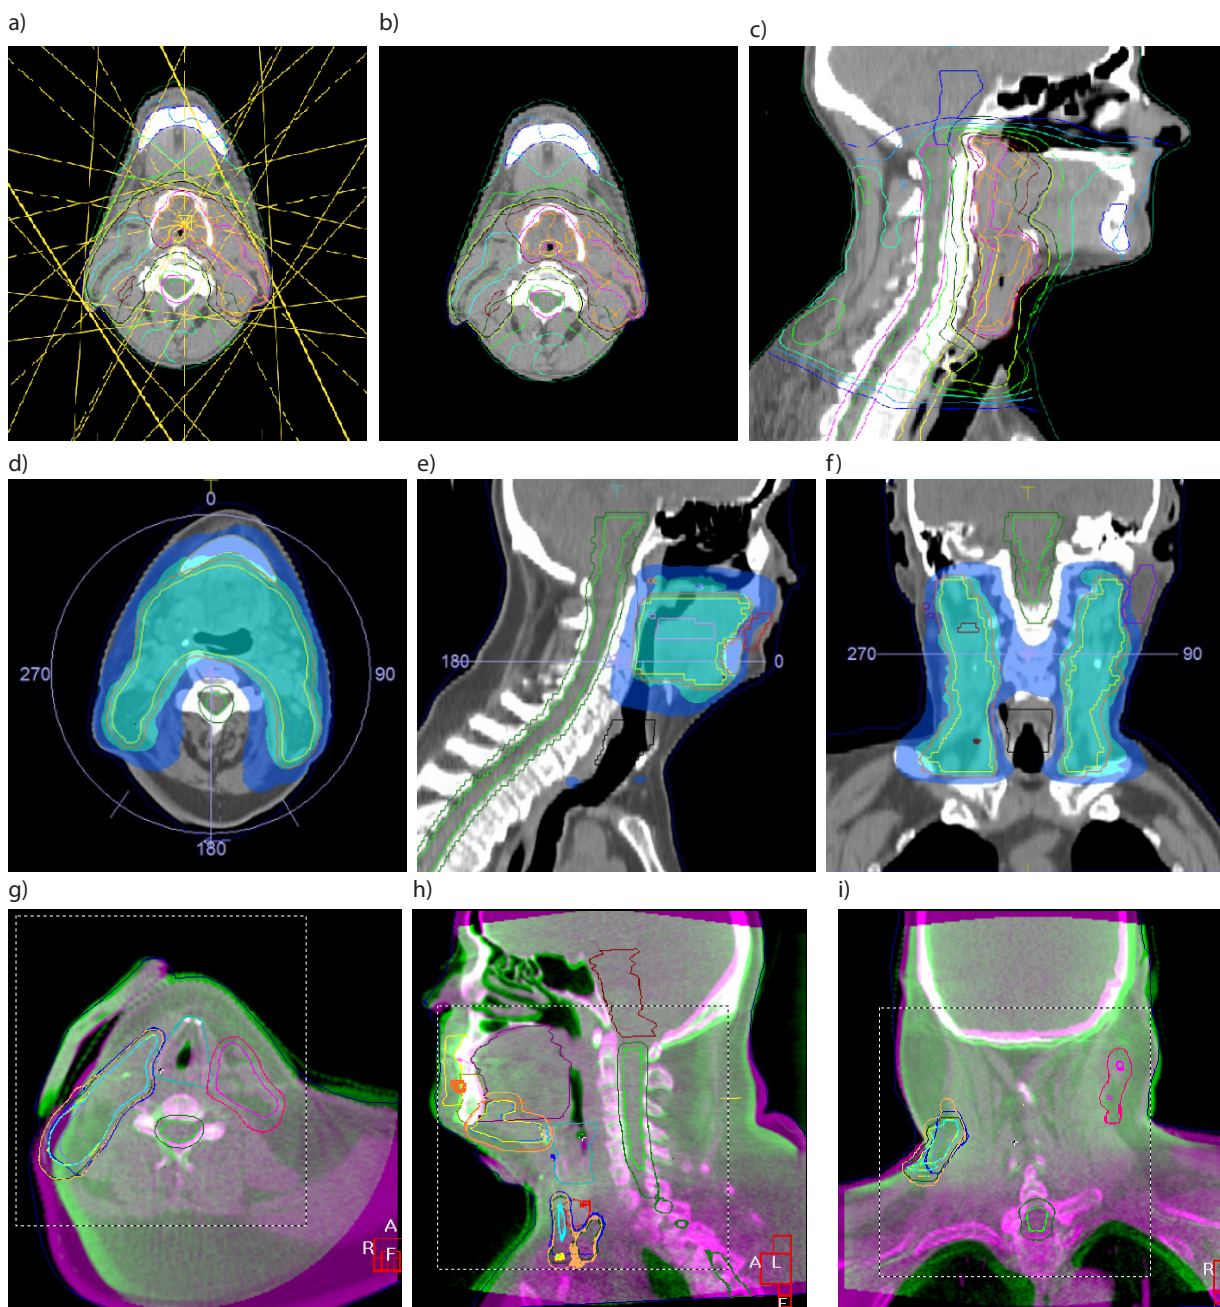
Use of computed tomography in radiotherapy planning and verification of the patient's positioning before starting radiotherapy. Radiotherapy planning with IMRT (intensity modulated radiotherapy): arrangement of radiation beams (a), distribution of radiation dose in the form of isodoses on the transverse cross-section (b) and sagittal cross-section (c). VMAT (volumetric modulated arc therapy) radiotherapy planning: distribution of the dose over the transverse (d), sagittal (e) and frontal (f) cross-sections. Verification of patient positioning by superimposing the location CT images (pink) and kV CBCT (cone beam computed tomography) made before irradiation (green) on the transverse (g), sagittal (h) and frontal (i) cross-section. The computer system reads shifts along the x, y, z axes and then corrects the position of the patient
